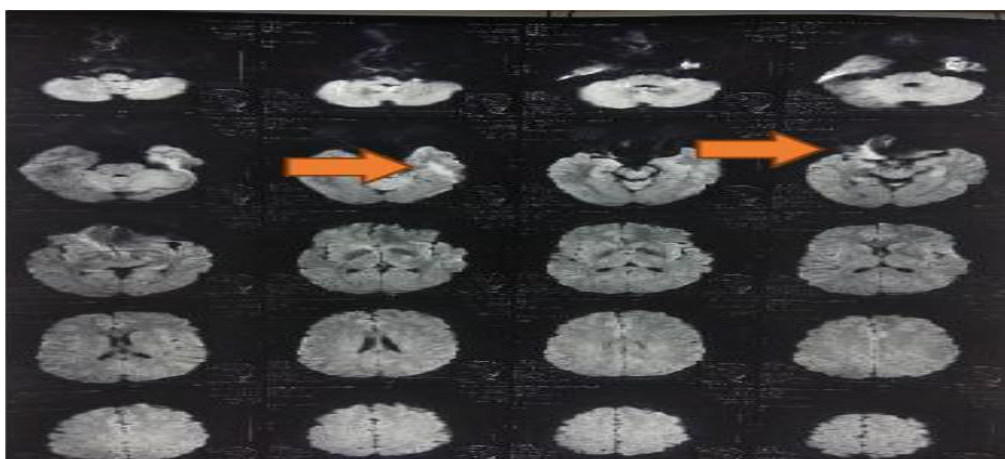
After administration of intravenous immunoglobulin. Brain MRI with and without contrast showing currently multiple hyperintense lesions on T2W1/Flair in centrum semiovale, corona radiata, and periventricular both sides, no patchy enhancement on contrast administration, there was improvement in radiological impression.
